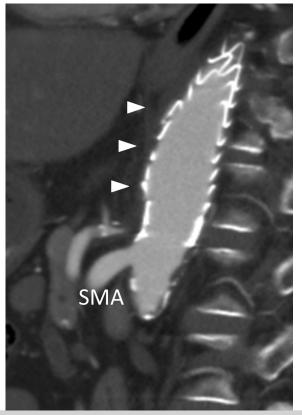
Contrast-enhanced computed tomography (CT) scan (6 months after the operation). The aneurysm has completely disappeared. No endoleak was found (*arrowheads*). *SMA*, Superior mesenteric artery.
